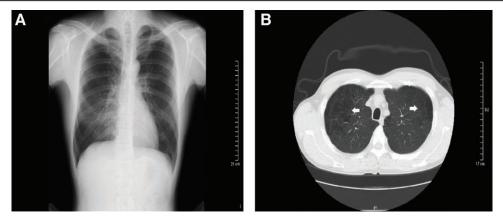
(A) CR of Case 24 described in Table 5. There was no abnormal opacity. (B) LDCT of Case 24 described in Table 5. There were a number of low attenuation areas on the bilateral upper lobes (white arrows). This case was diagnosed as COPD. COPD = chronic obstructive pulmonary disease, CR = chest radiography, LDCT = low-dose computed tomography.
